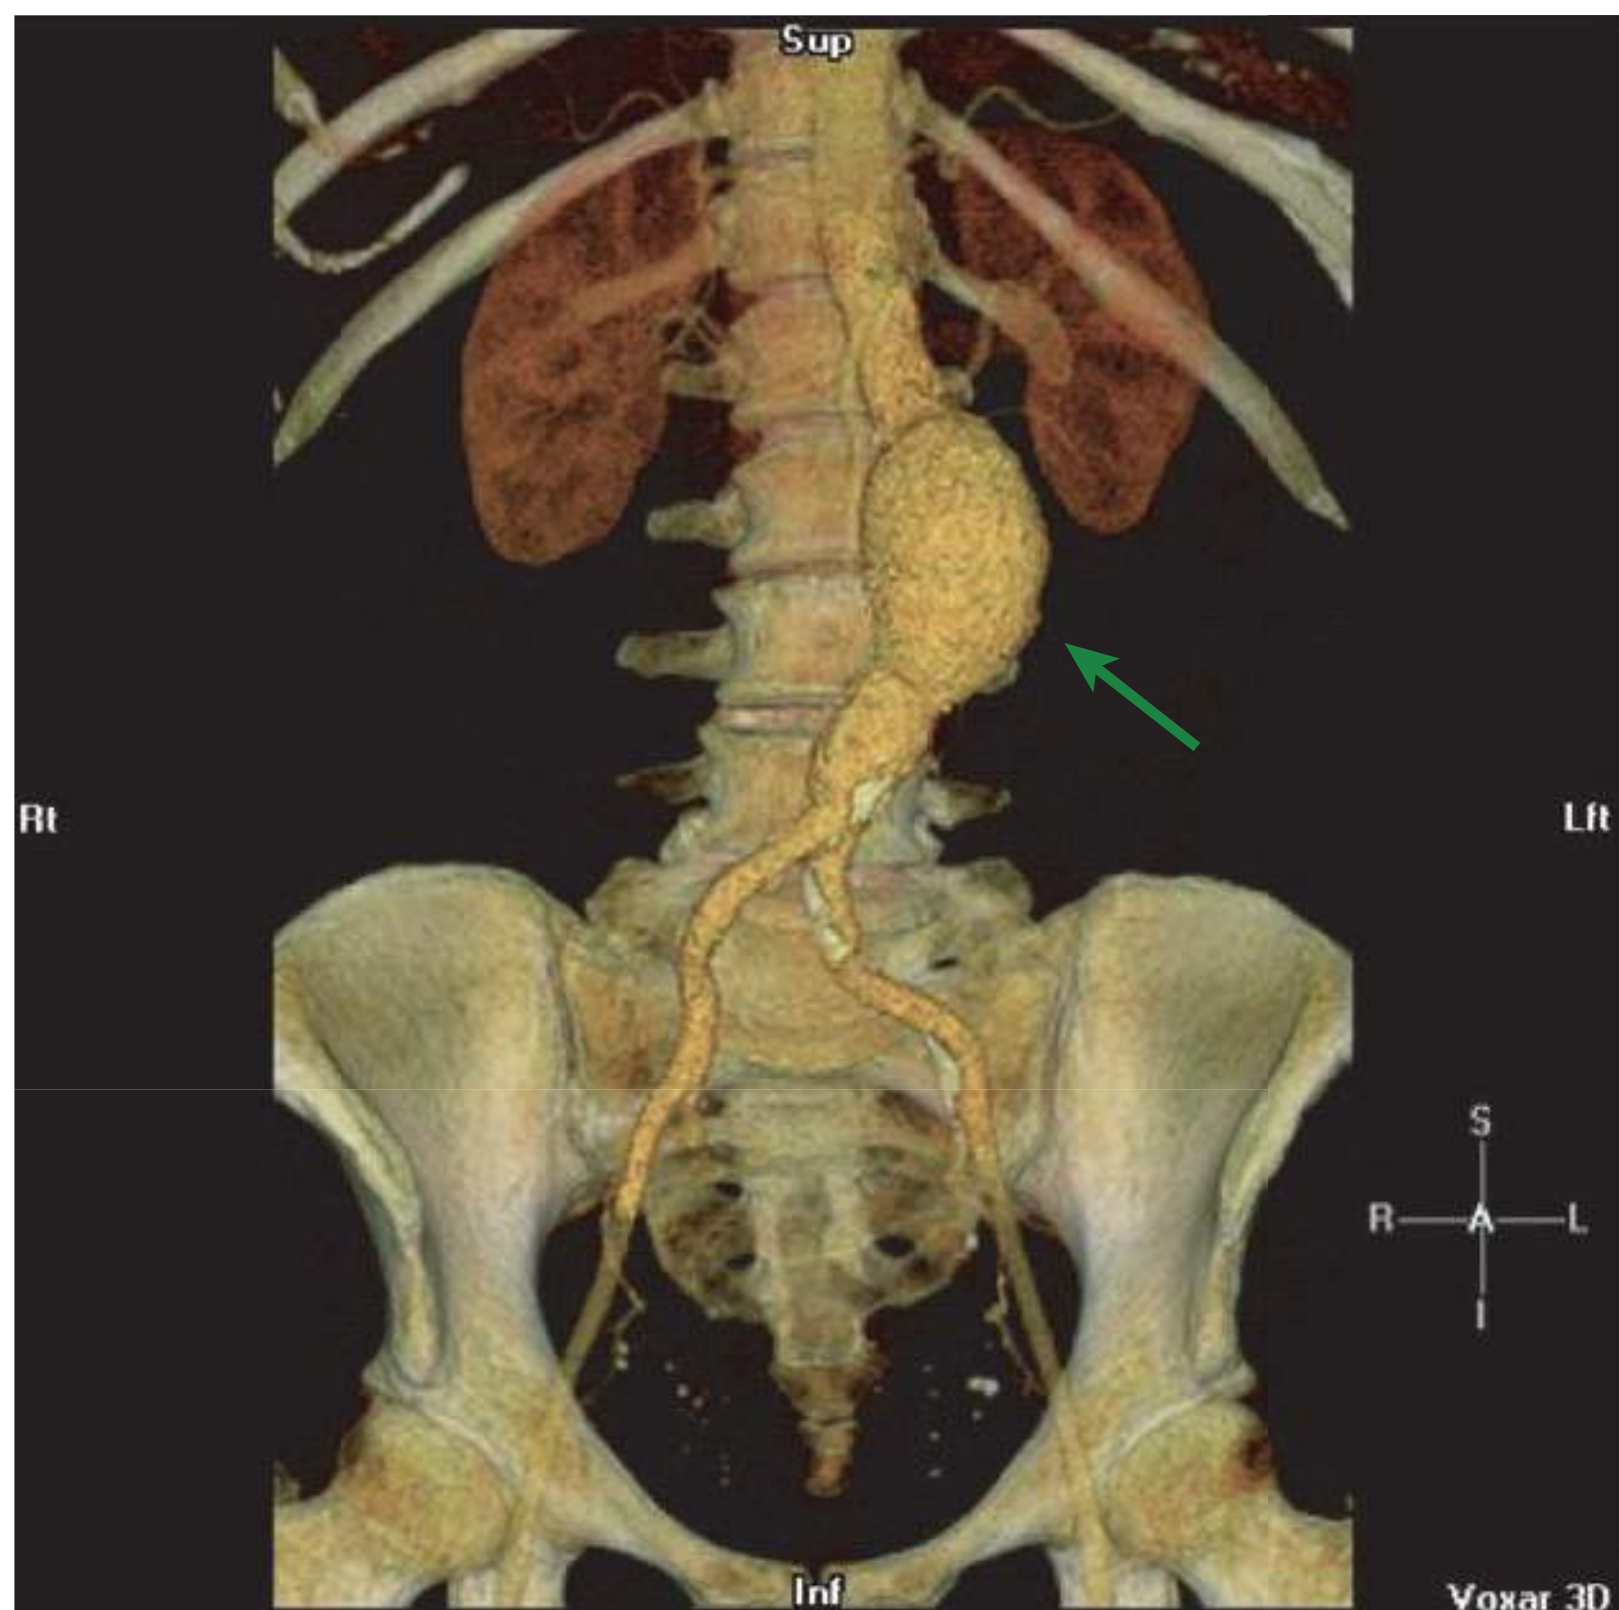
Abdominal aortic aneurysm. Computed tomographic angiogram (CTA) of an abdominal aortic aneurysm, indicated by the green arrow. (Courtesy of Frank Rybicki MD, Brigham and Women's Hospital, Boston, MA)
